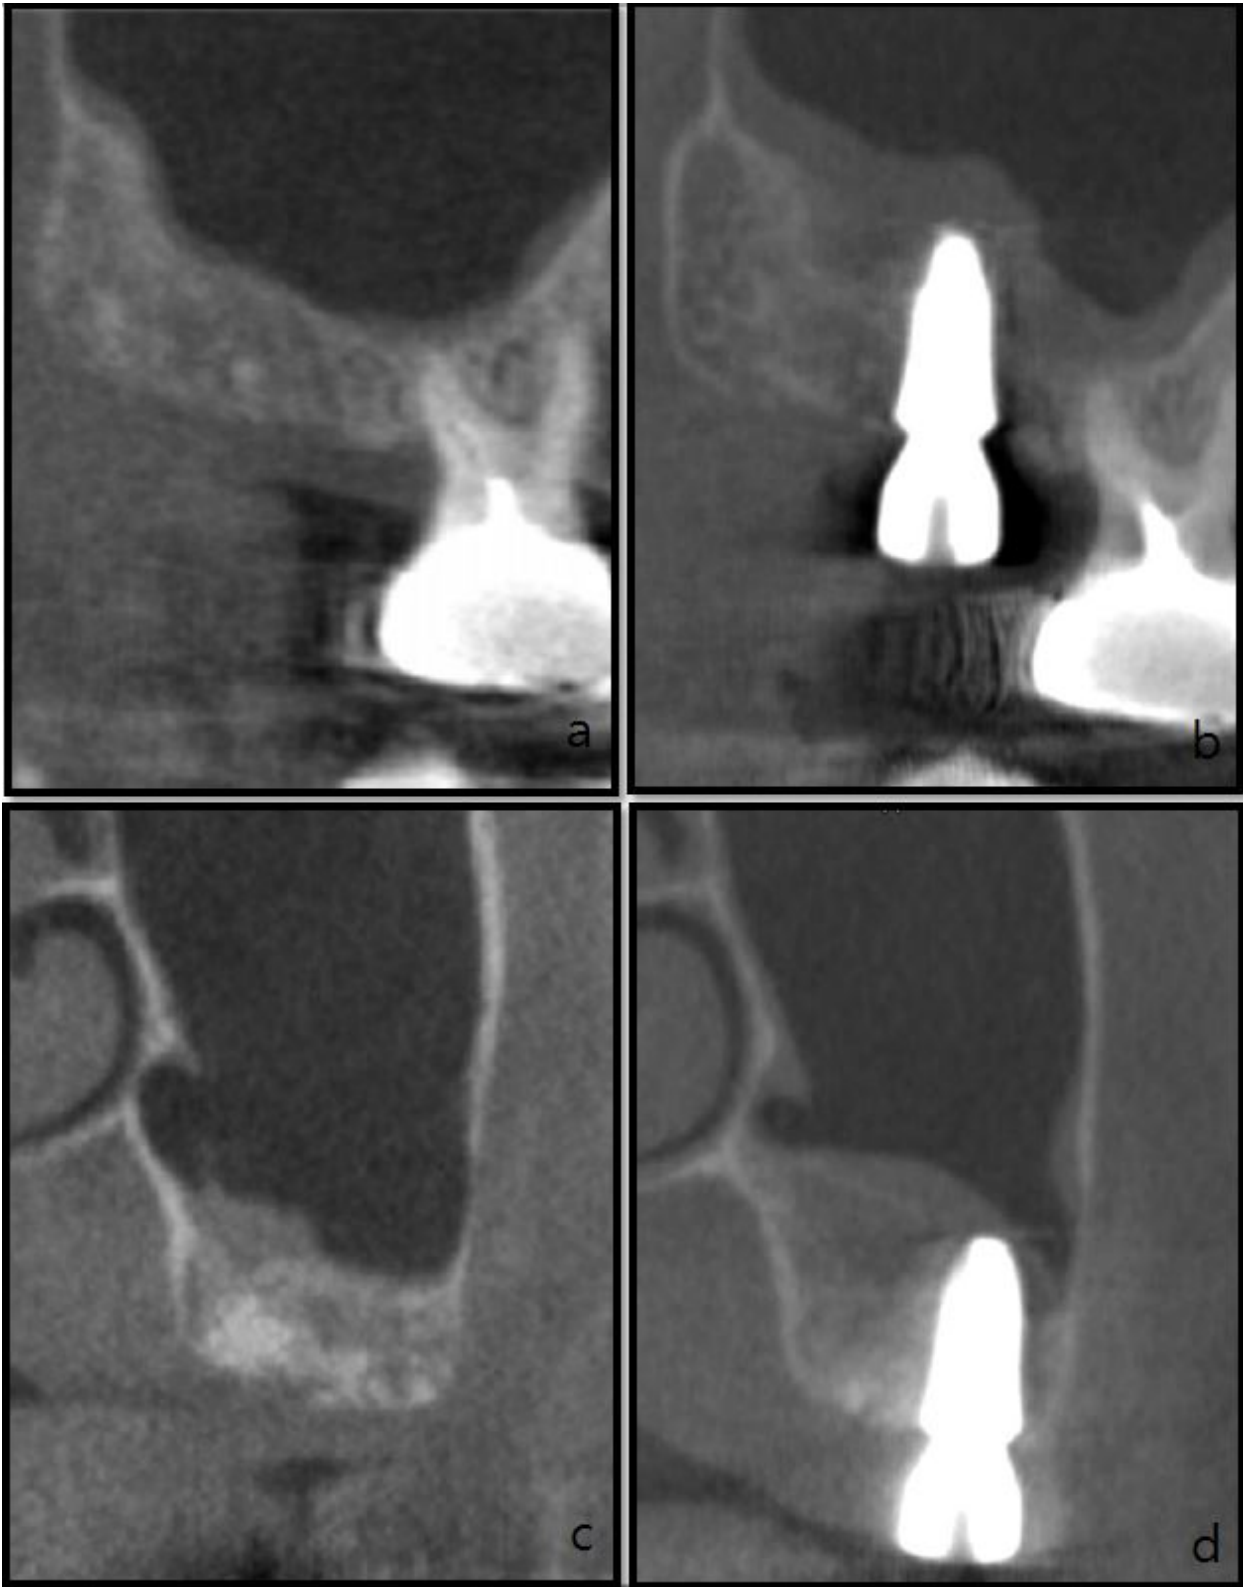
a)CBCT(4 months after treatment) b)CBCT(Implant installation with crestal approach, 7 months after treatment)
